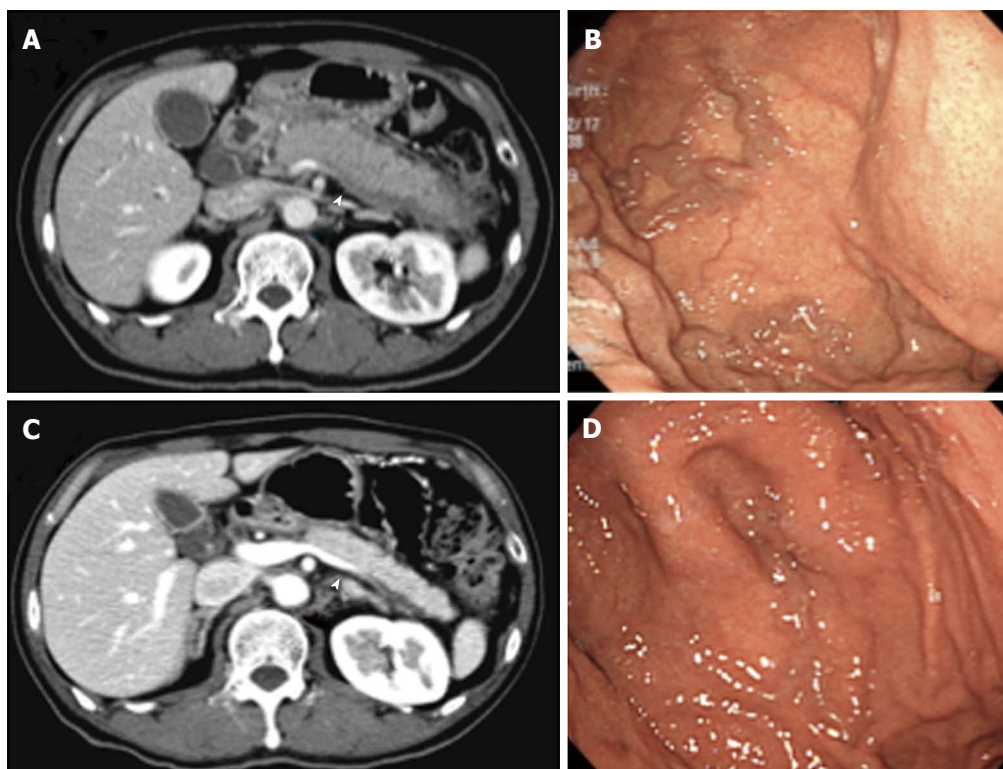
Disappearance of gastric varices following steroid therapy. A: Computed tomography showed a diffusely enlarged pancreas with a capsule-like rim, obstructed splenic vein (arrowhead), and dilated common bile duct; B: Esophagogastroduodenoscopy showed gastric varices in the fundus of the stomach; C: The splenic vein was reperused (arrowhead), and autoimmune pancreatitis improved following steroid therapy; D: Gastric varices disappeared following steroid therapy.
